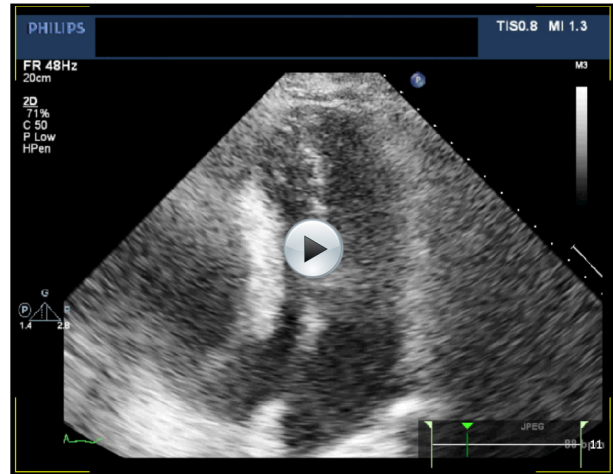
Transthoracic echocardiographic image (apical 4 chamber view) showing extrinsic compression of the right heart by the seroma.
